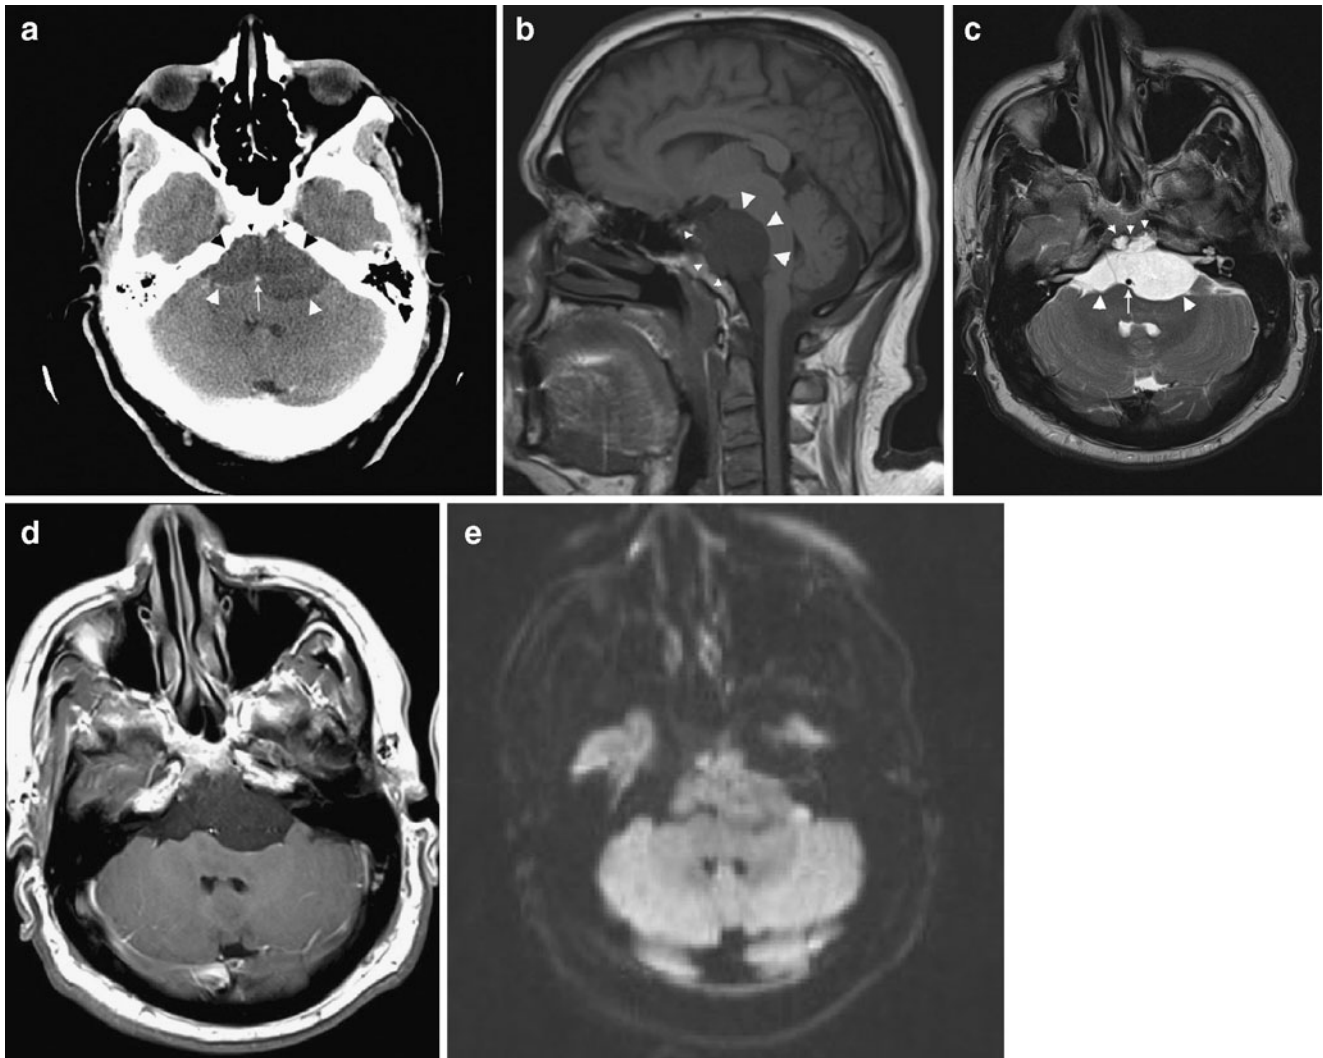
A 43-year-old male presenting with headache. a Axial contrast enhanced CT scan through the posterior fossa. There is a large hypodense lesion (*large arrowheads*) in the prepontine cistern, encasing the basilar artery (*arrow*). Note the irregular bony delineation of the clivus (*small arrowheads*). b Sagittal SE T1-weighted. There is a large hypointense lesion in the prepontine cistern, compressing the brain stem (*large arrowheads*). Note the relation to the clivus. The latter is partially hyperintense due to the fat and partially hypointense due to invasion by the lesion (*small arrowheads*). c Axial TSE T2-weighted image through the posterior fossa (same level as a). Large hyperintense mass lesion in the prepontine cistern with compression of the brainstem and cerebellum (*large arrowheads*), encasing the basilar
